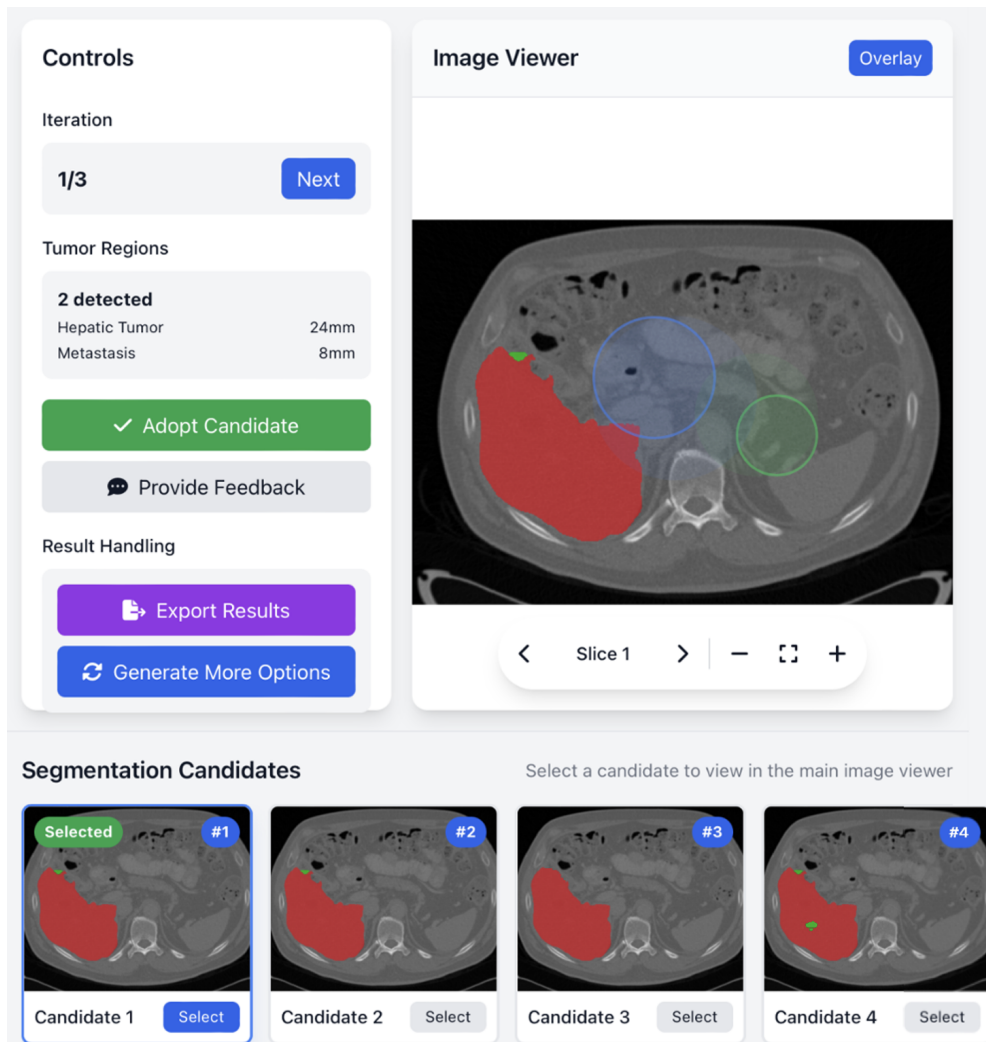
User interface design of our proposed user-preference alignment segmentation framework. The left panel includes controls for navigating through segmentation iterations, tumor region summary, and buttons for exporting results or generating additional segmentation options. The central panel displays the selected CT slice with liver and tumor segmentation overlays. Below, multiple segmentation candidates are presented to facilitate efficient user preference alignment and iterative refinement.
